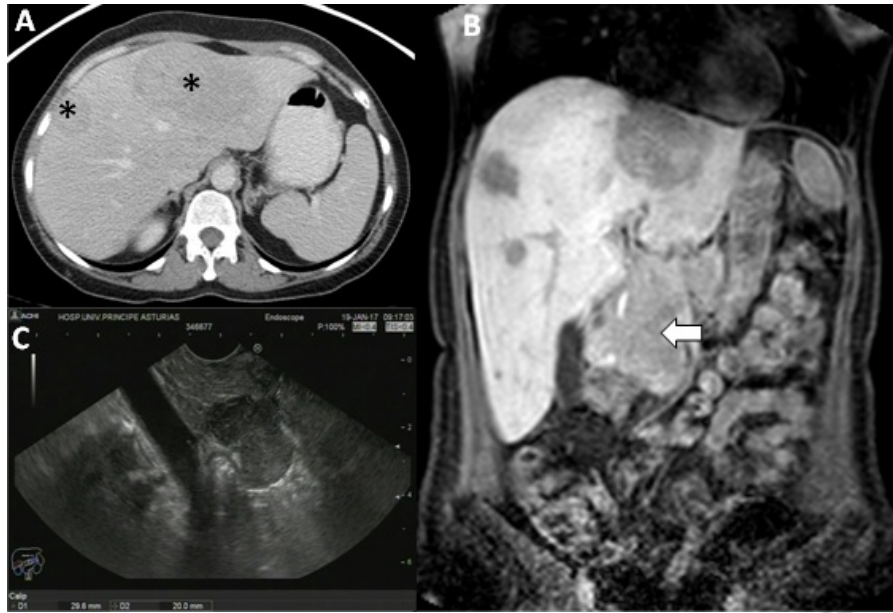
A. CT section showing hypodense SOLs in the liver (asterisks). B. MRI with liver-specific contrast, late phase. Coronal reconstruction. A mass is visible in the uncinata process (arrow). C. Echoendoscopy image showing well-delimited hypochoic SOL in the uncinata process.
